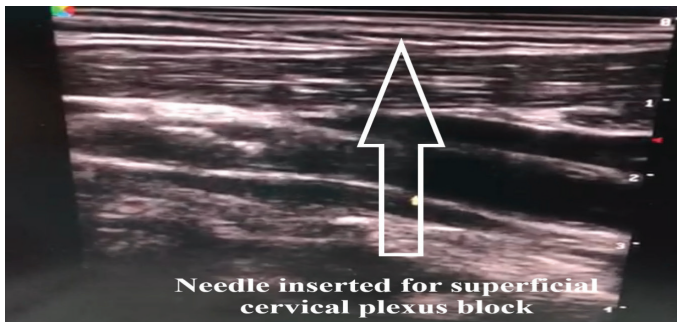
Ultrasound guided cervical plexus block
